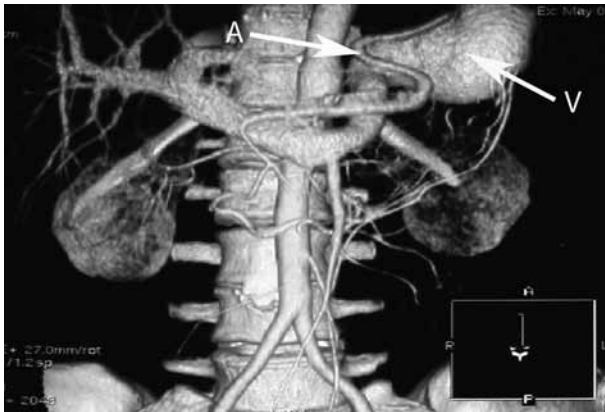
Abdominal angiography computed tomography reconstruction. Coronal reconstruction of splenic arteriovenous fistula (A-splenic artery, B-splenic vein).
